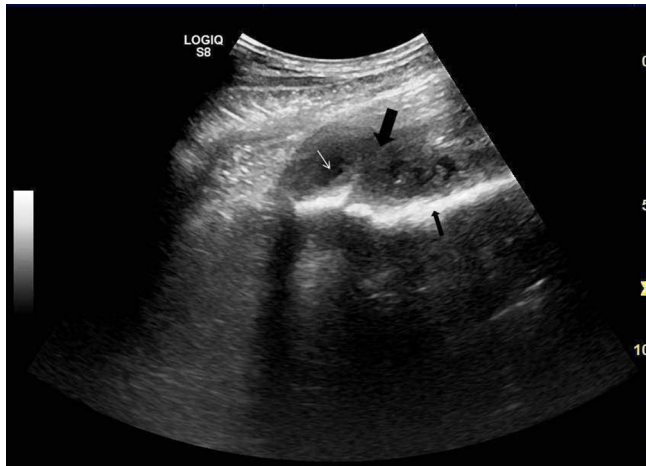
Long axis grey scale ultrasound image of the right/left lumbar region shows a large hypoechoic lesion (thick black arrow) in the psoas muscle seen anterior to the cortex of the lumbar spine (thin black arrow) with small anechoic areas (thin white arrow) within it (suggesting necrosis and thus abscess formation).
